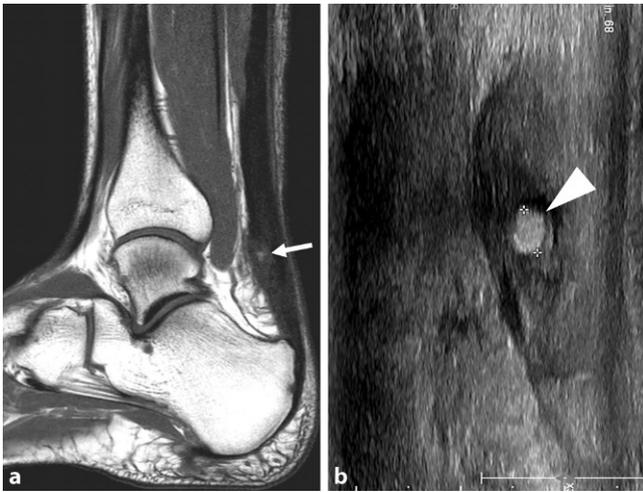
▲ MR image in the sagittal plane (a) at the 2-month follow-up, showing an internal focal hyperintense area in the repaired AT in the T1-weighted sequence (*arrow*). It could correspond to an intratendinous seroma but US examination (b) in the same plane very clearly shows the echogenic focal image of intratendinous residual fatty tissue (*arrowhead*)
